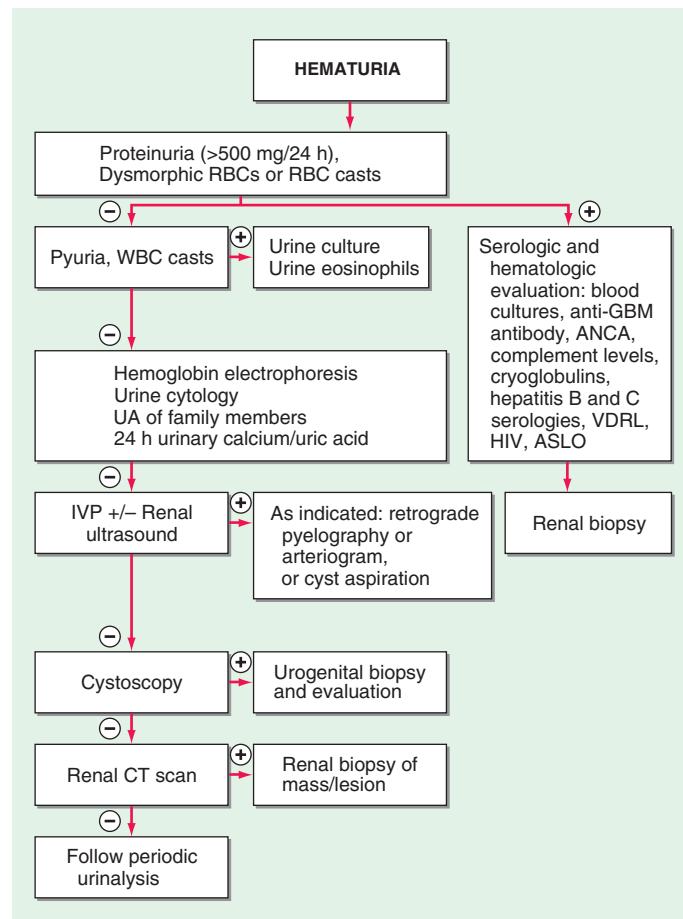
Approach to the patient with hematuria. ANCA, antineutrophil cytoplasmic antibody; ASLO, antistreptolysin O; CT, computed tomography; GBM, glomerular basement membrane; IVP, intravenous pyelography; RBC, red blood cell; UA, urinalysis; VDRL, Venereal Disease Research Laboratory; WBC, white blood cell.
